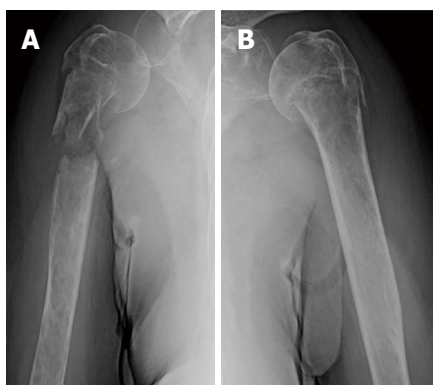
Anteroposterior radiographs of the humeri, showing bilateral proximal humeral pathologic fractures and underlying aggressive appearing ill-defined permeative lytic lesions, more pronounced in the right humerus.
